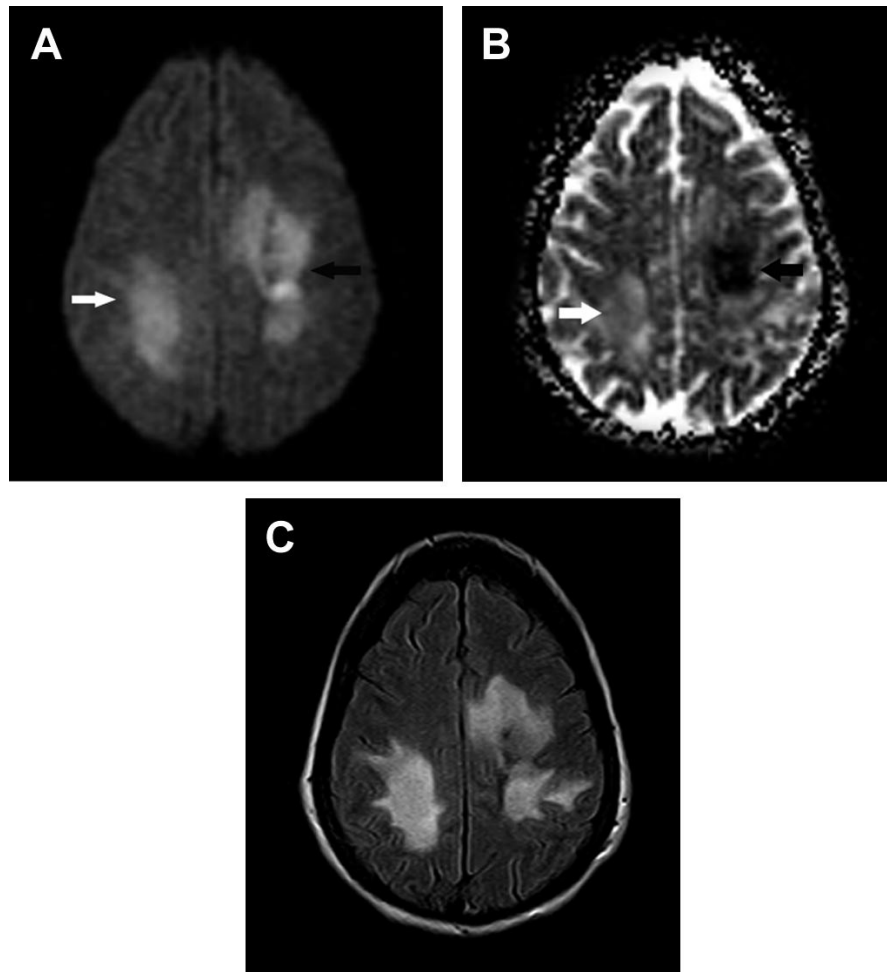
Magnetic resonance (MRI) scan showing a combination of cytotoxic and vasogenic edema. A, Diffusion-weighted sequence shows cytotoxic and vasogenic edema as bright signal; the bright signal corresponding to the area of vasogenic edema (white arrow) is due to “shine-through” effect from the T2 sequence. B, Apparent diffusion coefficient map clearly differentiates cytotoxic and vasogenic edema. Cytotoxic edema is associated with restriction in the movement of water molecules across the cellular membrane and thus with a low diffusion coefficient, which is seen as a dark signal (black arrow). Instead, vasogenic edema is associated with increased freedom of movement of water molecules, resulting in a high diffusion coefficient, which is seen as a bright signal (white arrow). C, Note that FLAIR sequence fails to distinguish between the 2 types of edema.
